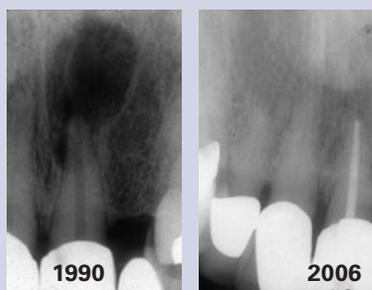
Pre- and post-operative radiographs of a central incisor treated with nonsurgical root canal therapy. Radiographs courtesy of Dr. Louis Rossman.
